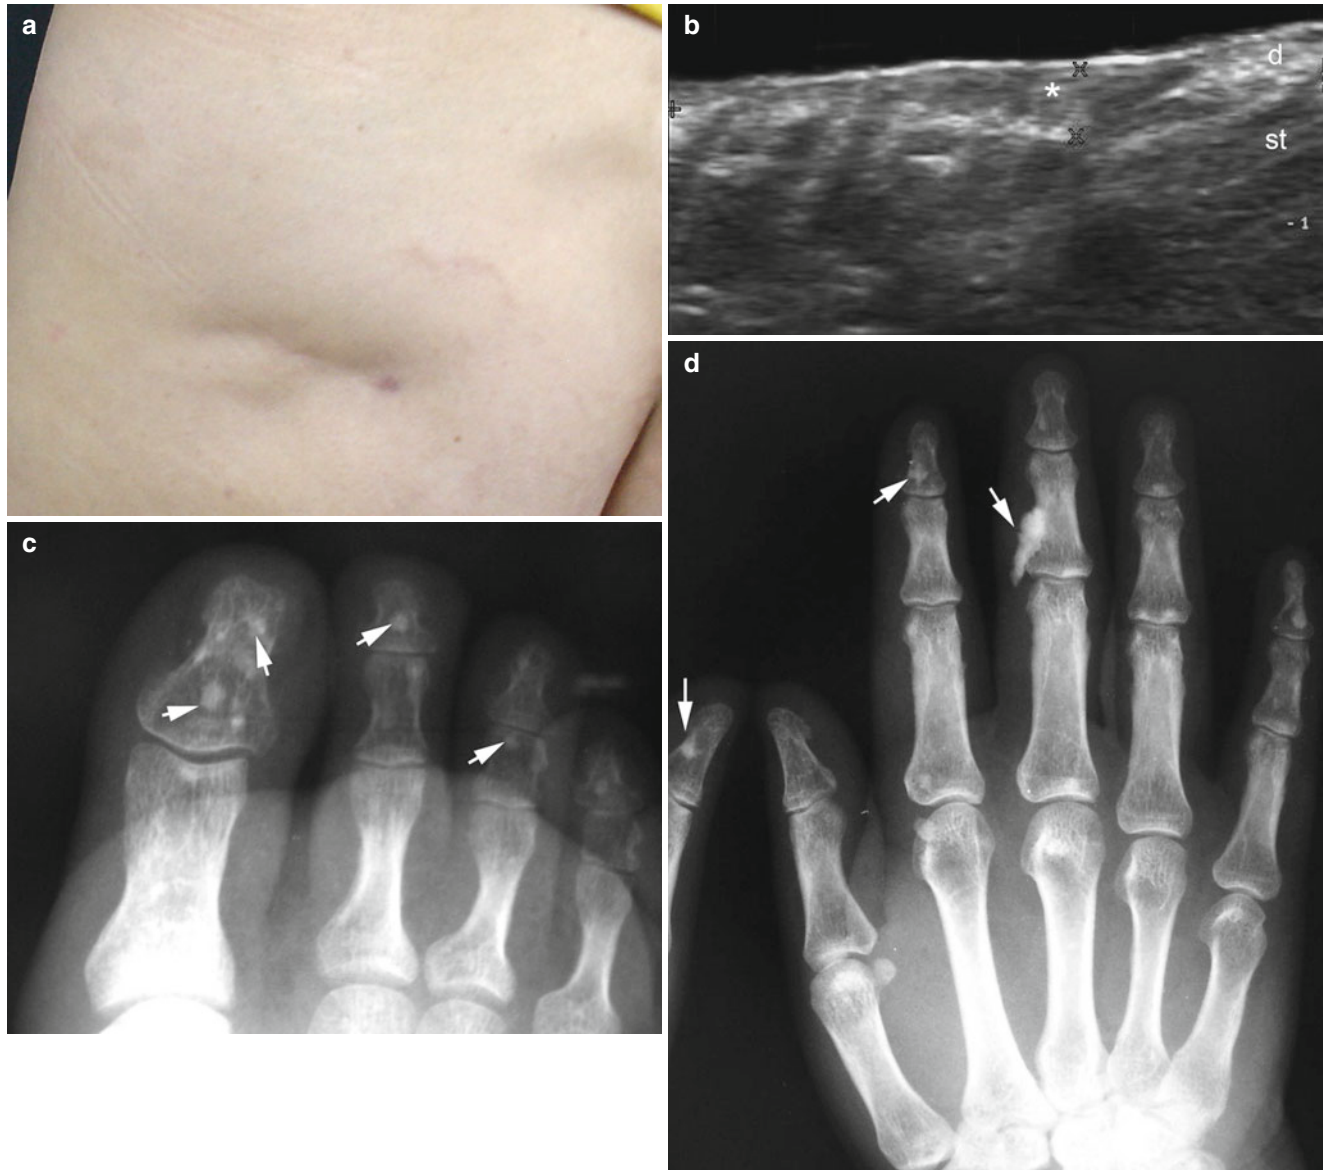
(a–d) Bushke-Ollendorf disease. (a) Clinical lesion in the left gluteal region. (b) Ultrasound image (gray scale, transverse view, left gluteal region) shows hypoechoic dermal thickening (*). (c, d) Radiographs (anteroposterior view) of the left foot (c) and left hand (d)
